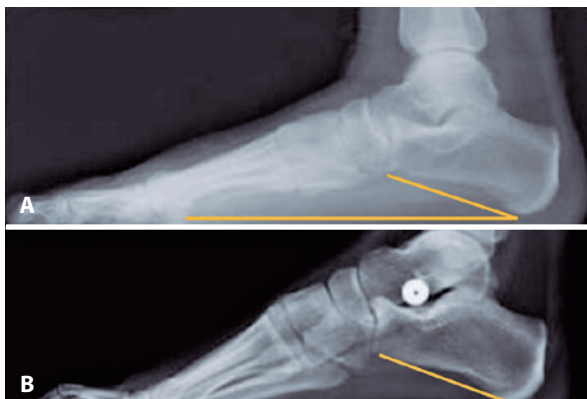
(A) Pre- and (B) postoperative radiographic images of a pediatric patient with FF who received arthroereisis with polyethylene synthetic material implantation and showed a satisfactory response to the surgical procedure. Source: Author's personal archive.
